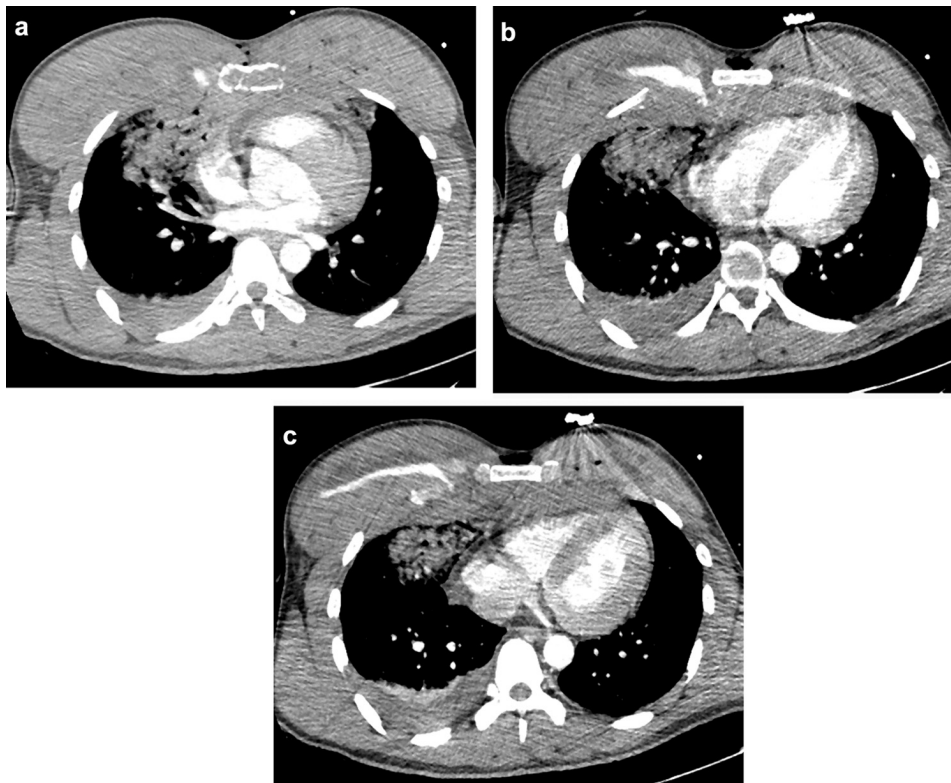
Contrast thoracic CT scan. (a): Sternal fracture, extensive retrosternal haematoma, right pulmonary contusion and pleural effusion, limited pericardial effusion. (b) and (c): Lack of contrast medium showing an active bleeding of the right mammary artery.
